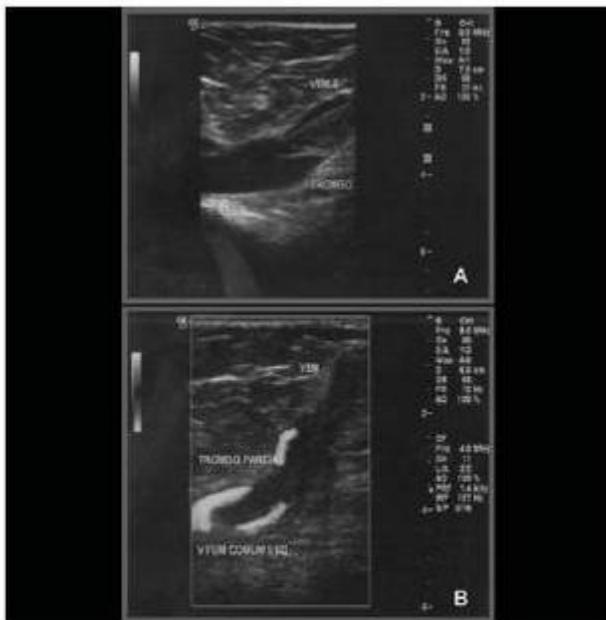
Duplex scan of superficial thrombophlebitis, showing image of partial thrombus in the great saphenous vein and in the common femoral vein: A) mode B: hyperechogenic image of thrombus in the great saphenous vein going into the common femoral vein; B) powerDoppler image showing partial flow around the thrombus in blue
